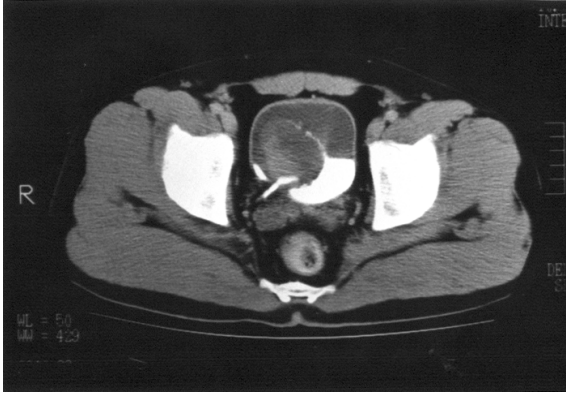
Enhanced CT of the pelvis shows a rounded mass of heterogeneous density located at the right posteroinferior aspect of the bladder.
